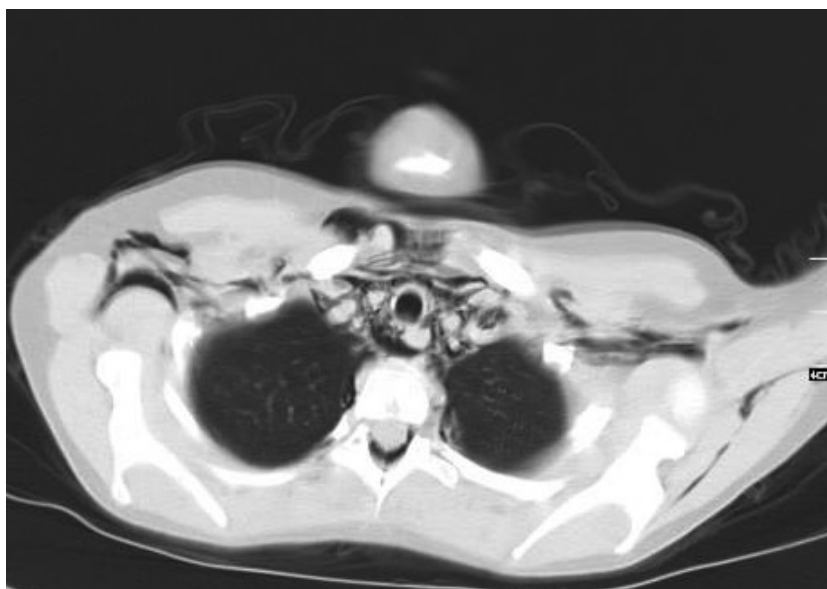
CT scan of the chest demonstrating air in the mediastinum, epidural space and subcutaneous tissue.
